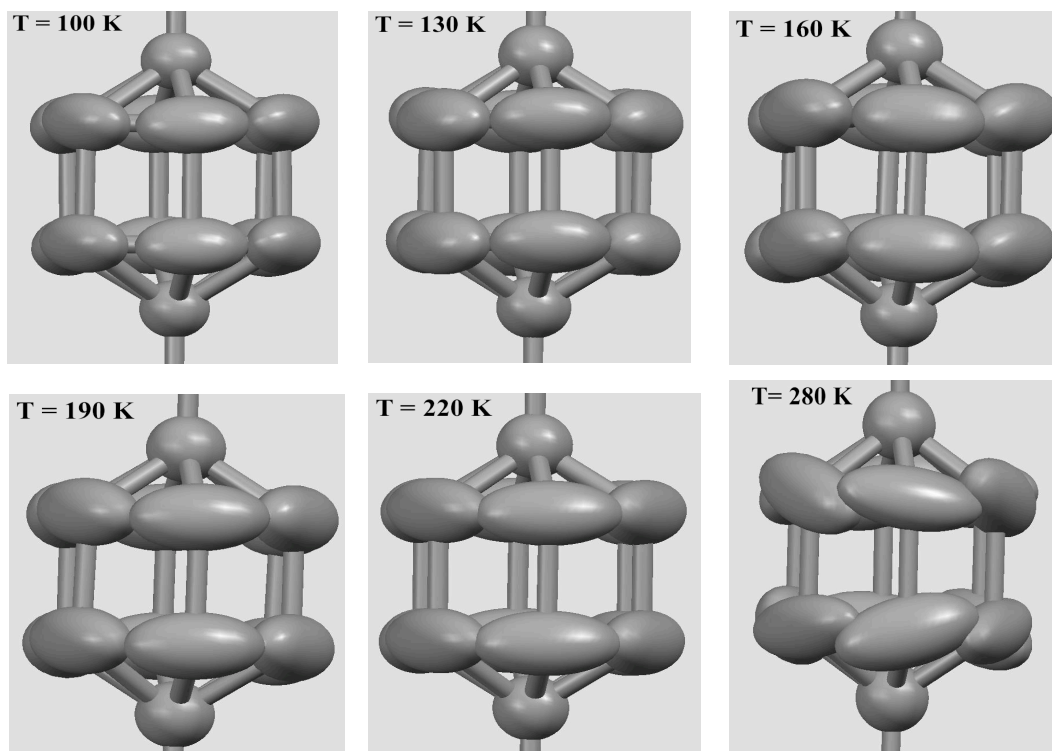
X-Ray structures of the phenyl ring part of the phenyl rod rotor at variable temperature, showing the increase of the ellipsoid size with increasing temperature.
